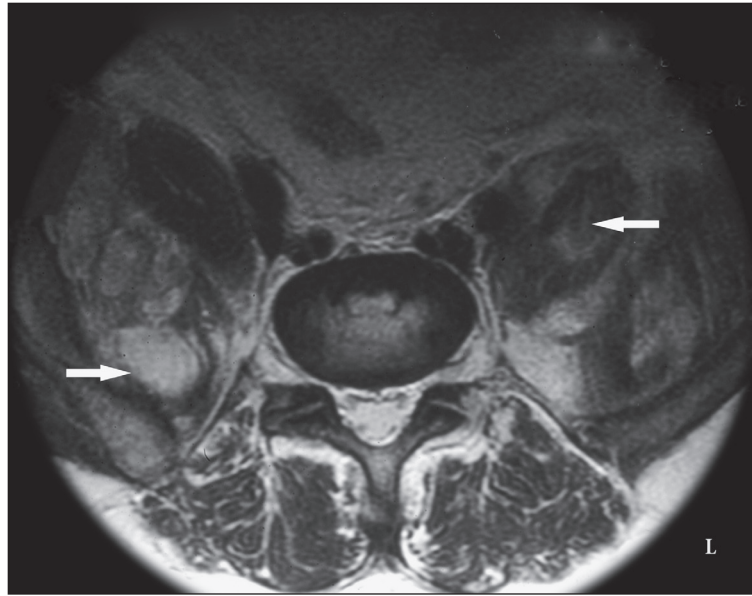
Gadolinium-enhanced axial inversion time MRI sequences of abdomen revealing bilateral enlarged heterogeneous hyperintense signals in both iliopsoas muscles (arrows).
